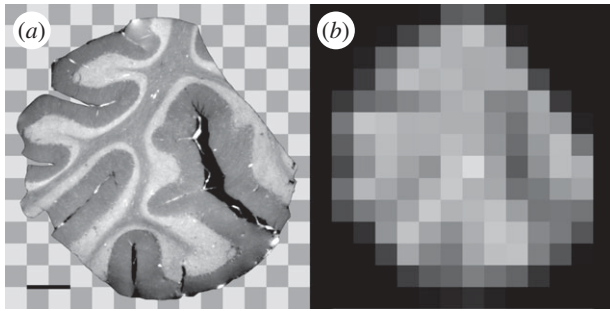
A 100-fold binning of the phase-contrast results reveals the distinction of the spatial resolution between SR μ CT and contemporary medical MRT. For that, we assumed a pixel size of 0.5 mm for nowadays common medical high-resolution MR-results. The black bar corresponds to 1 mm.
